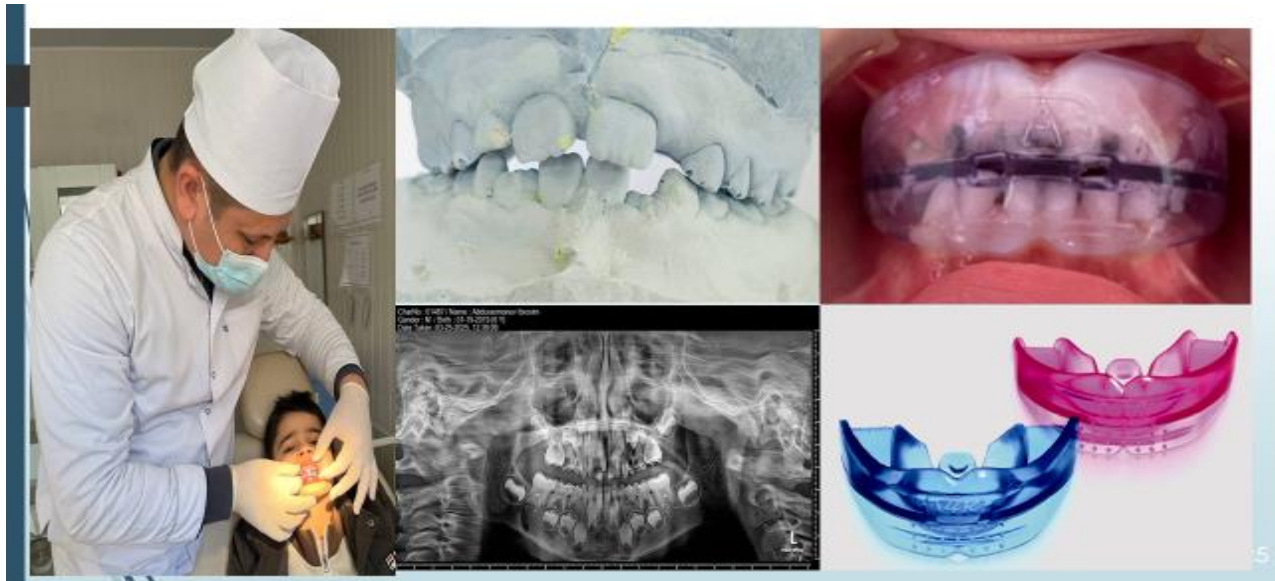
Clinical, radiographic, and laboratory findings in a patient with insufficient arch space during mixed dentition, including intraoral examination, plaster diagnostic models, panoramic radiograph, and removable orthodontic appliances
